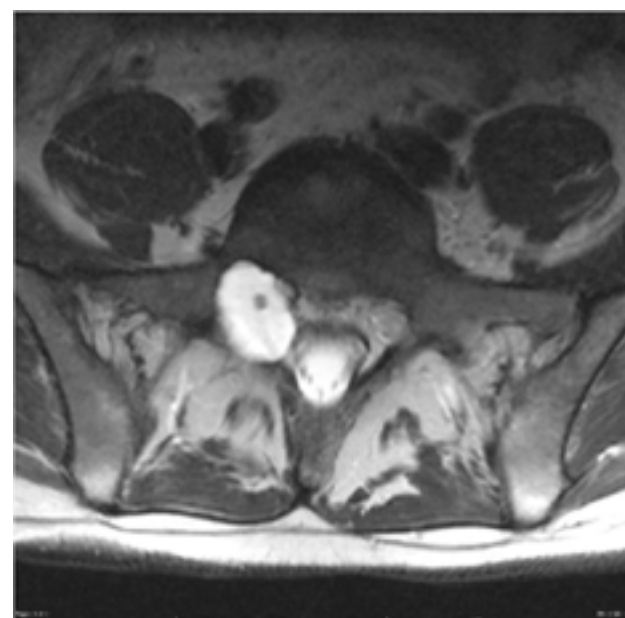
Tarlov Cyst on axial view on MRI imaging with bone scalloping
